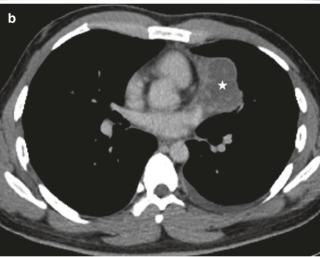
28-year-old man with seminoma. (a) Frontal radiograph shows a left paramediastinal mass silhouetting the left heart border but preserving the descending aorta shadow. (b) Axial CT image shows a well-circumscribed lobulated mass in the anterior mediastinum with heterogeneous enhancement
